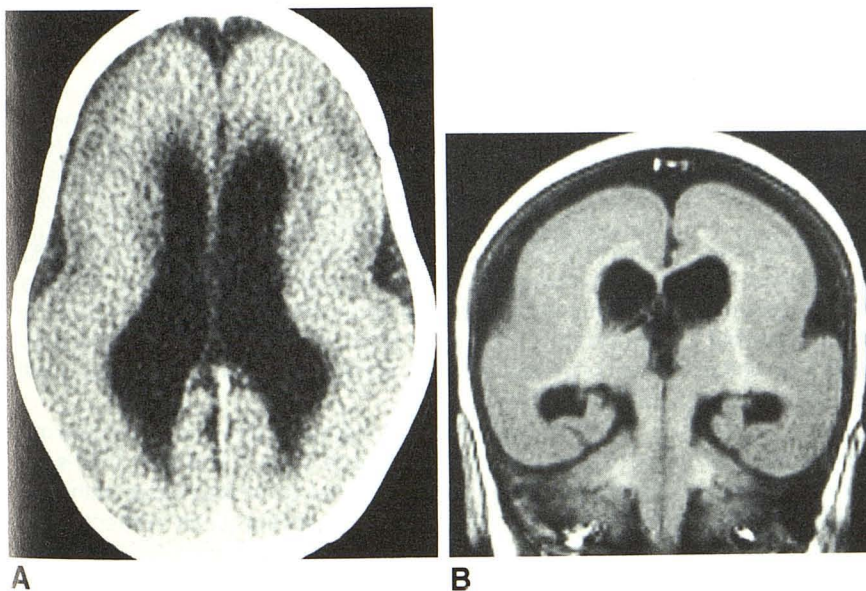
Axial enhanced CT scan (A) and coronal MR image, 500/30 (B). Completely agyric brain with oval configuration, shallow sylvian grooves, increased cortical gray matter and relatively small amount of white matter, and absence of normal cortical white-matter interdigitations.
